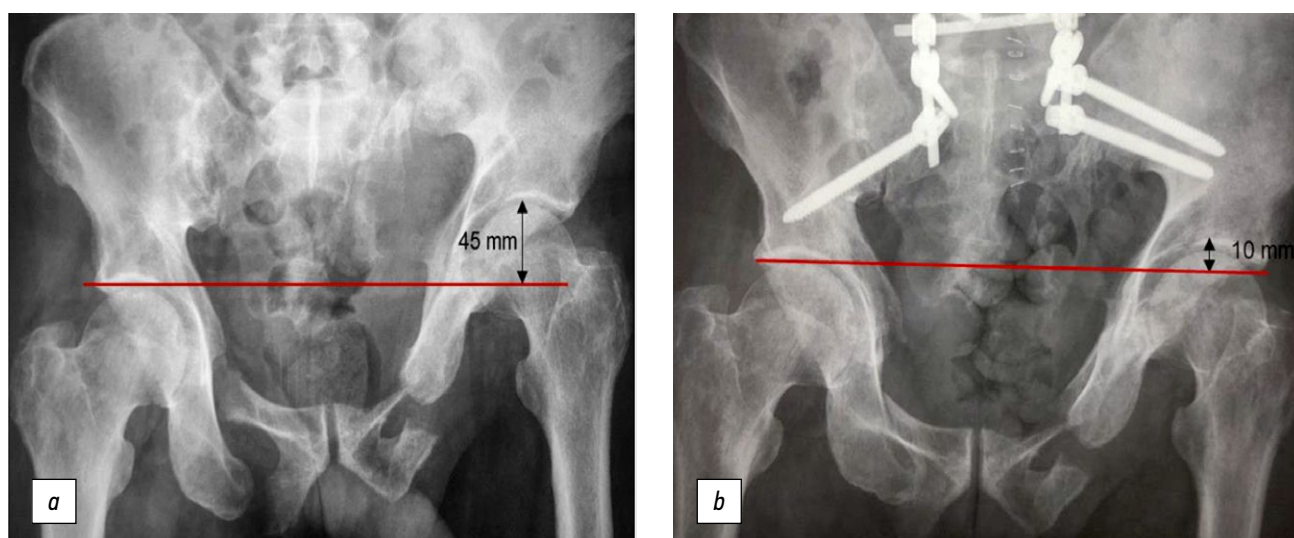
Overview radiography of the pelvis: *a* — before surgical treatment; *b* — after spino-pelvic fixation with open repositioning of the left hemipelvis.
